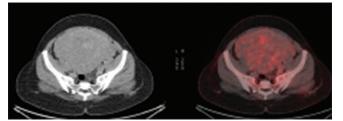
PET-CT axial images also show large mass occupying almost entire pelvic cavity
